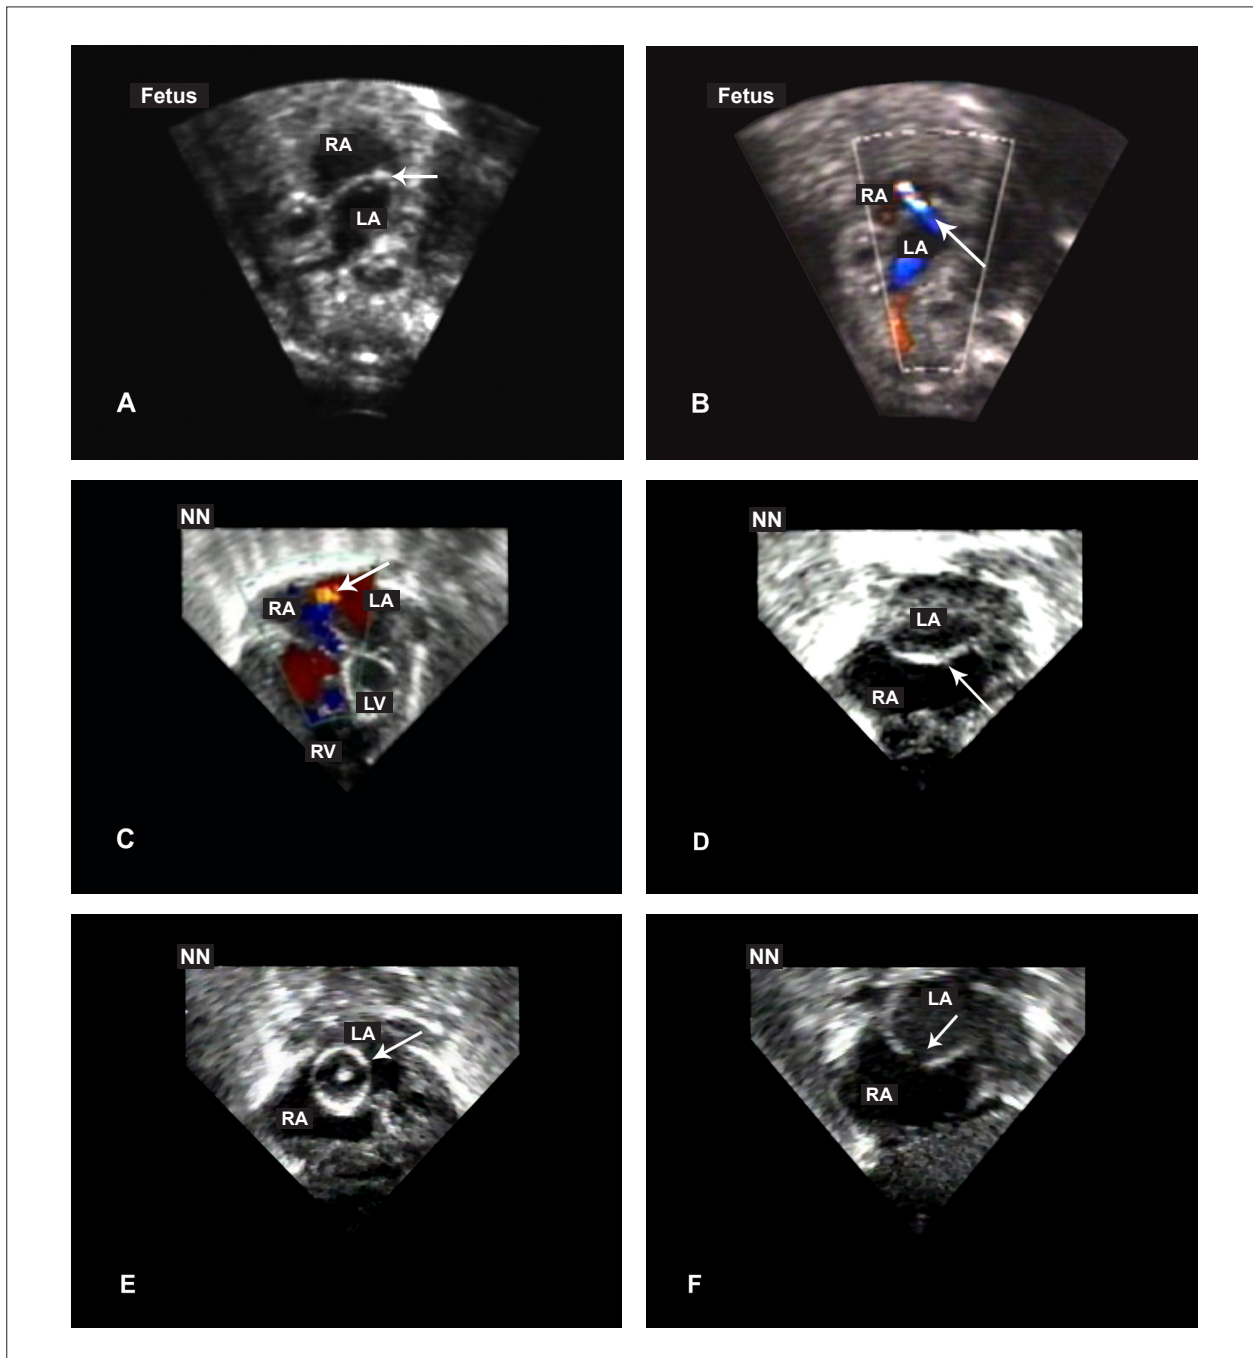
Balloon atrial septostomy monitored by echocardiography in hypoplastic left heart syndrome with severely restrictive foramen ovale. A and D) Fetal and pediatric echocardiogram showing a practically closed interatrial septum, with no visible foramen at the two-dimensional echocardiogram. B and C) Color-flow mapping confirming the extremely restrictive foramen ovale through a thin and high-velocity flow. E) Inflated balloon in the LA. F) Atrial septal defect created after balloon septostomy. RA - right atrium; LA - left atrium; RV - right ventricle; LV - left ventricle.
